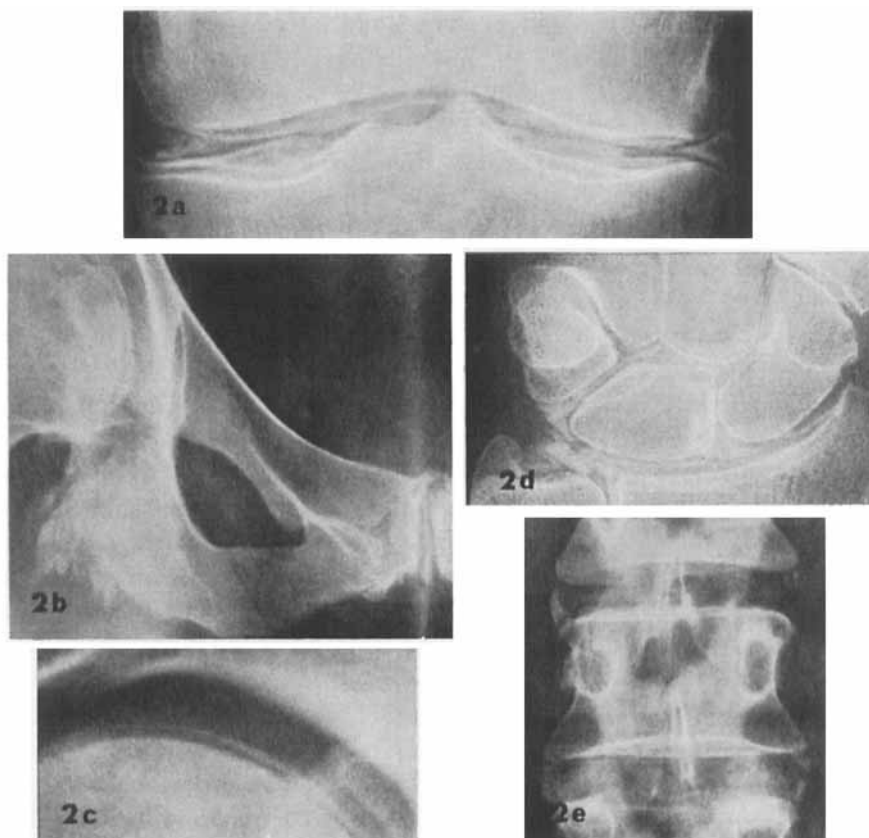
Details of X-ray films showing typical cartilage calcifications in the (a) knee, (b) pelvis, (c) shoulder, (d) wrist and (e) lumbar spine.
